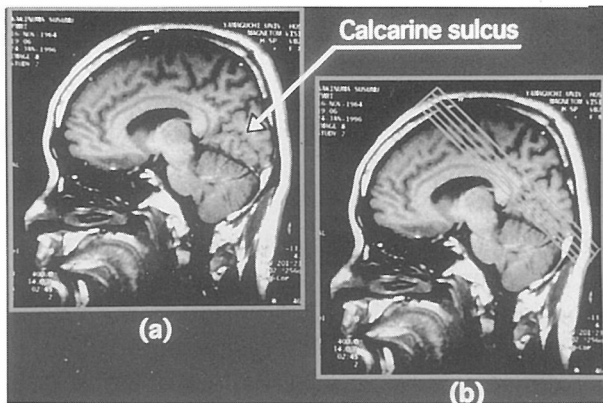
Anatomic definition of the brain section used for functional imaging of the visual cortex. (a) Sagittal T1 weighted MRI image. The arrow points to the calcarine sulcus. (b) The obliquity of the transverse slices was chosen to include a large part of the calcarine sulcus.
